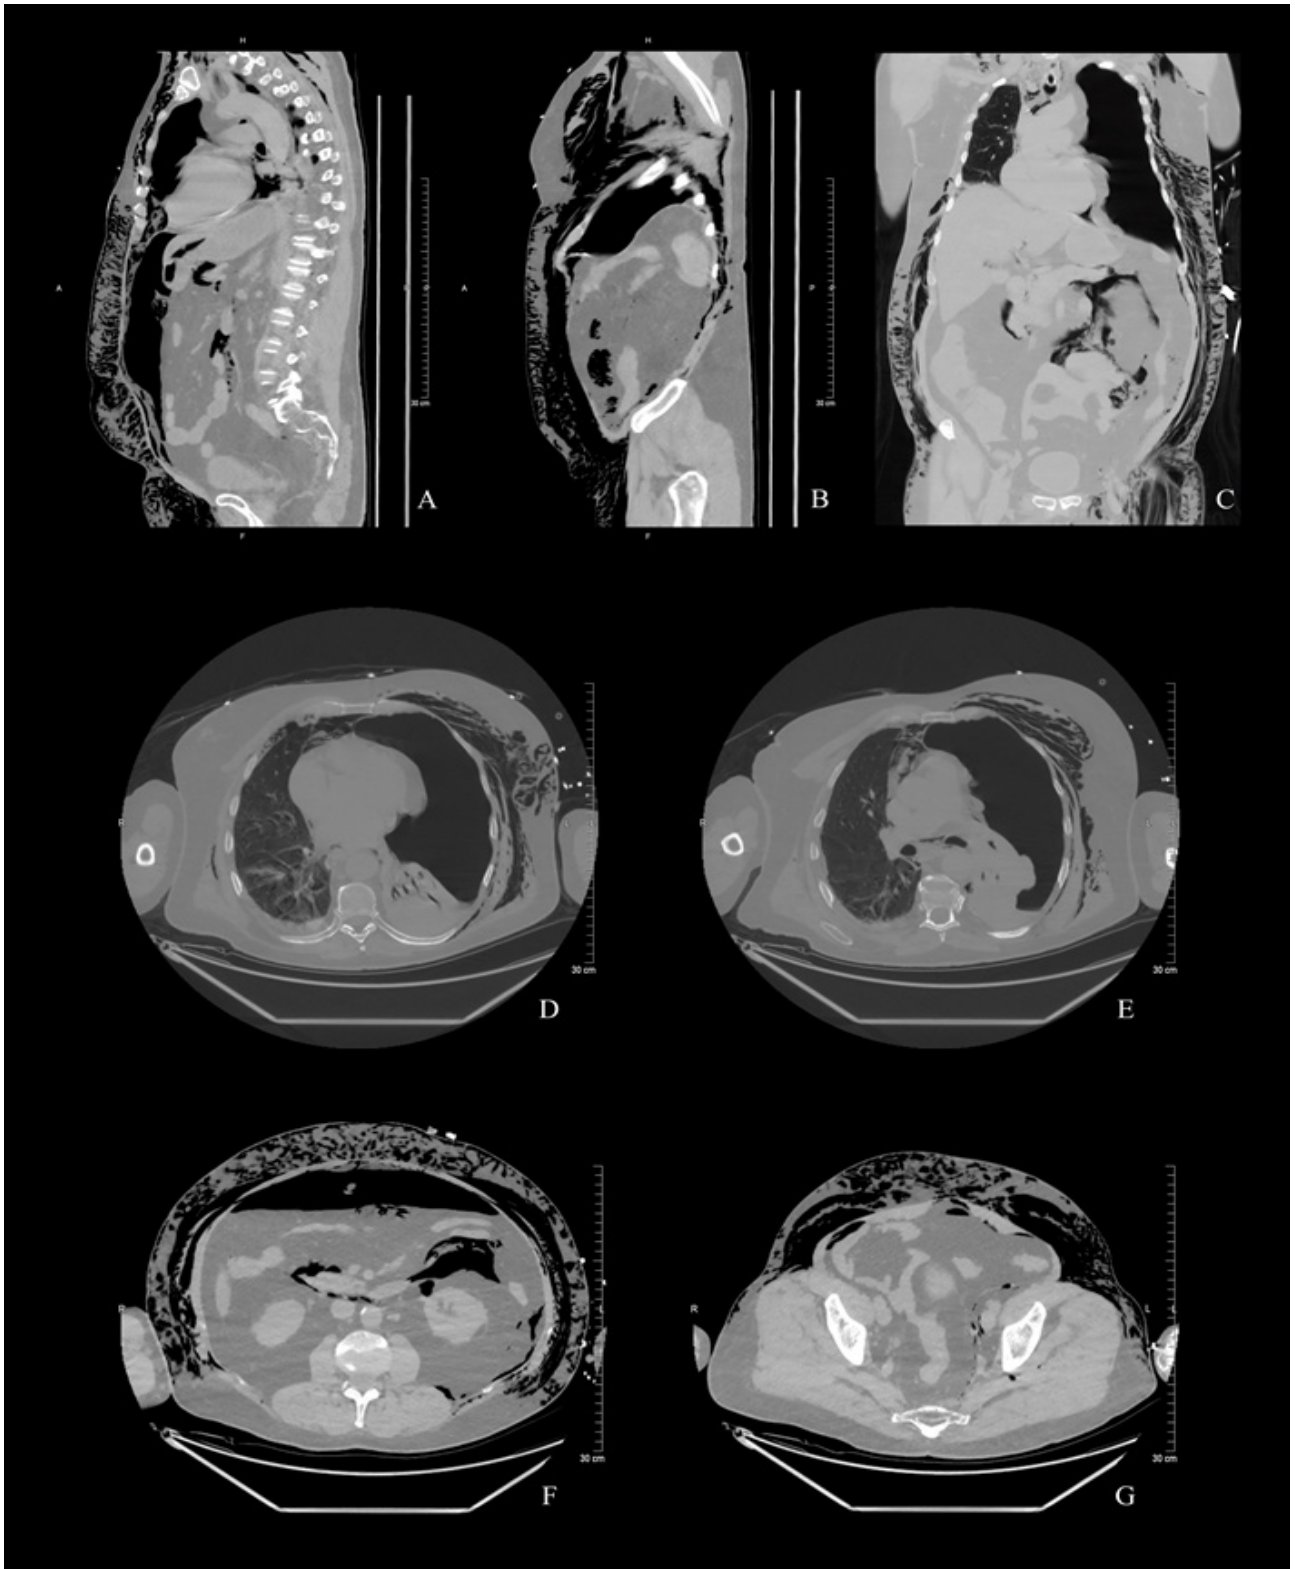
Chest-abdomen-pelvis CT scan findings. A, B - sagittal reconstructions; C - coronal reconstruction, D - G axial view: massive left pneumothorax with left lung collapse and mediastinal dislocation to the right, pleural effusion on the right, pneumomediastinum, pneumoretroperitoneum, pneumoperitoneum, subcutaneous emphysema.
